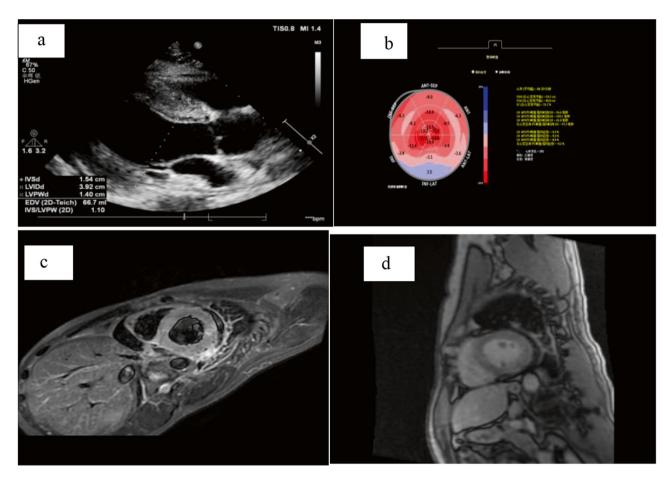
a TTE performed during hospitalization shows thickened left ventricular wall, about 15 mm. b Spot tracking technology (STI) of heart showed normal strain in the left ventricular apex, reduced strain in the basal segment of the left ventricle, thickening of the left ventricular myocardium with echocardiographic changes, and left ventricular systolic dysfunction with an LVEF of 31.7%, thus suspected cardiac amyloidosis (CA). c CMR indicated regional myocardial thickening, thinned anterior and lateral walls of the left ventricular apex during diastole, and a small amount of pericardial effusion. d CMR follow-up indicates that there are no significant abnormalities in myocardial thickness and endocardium
